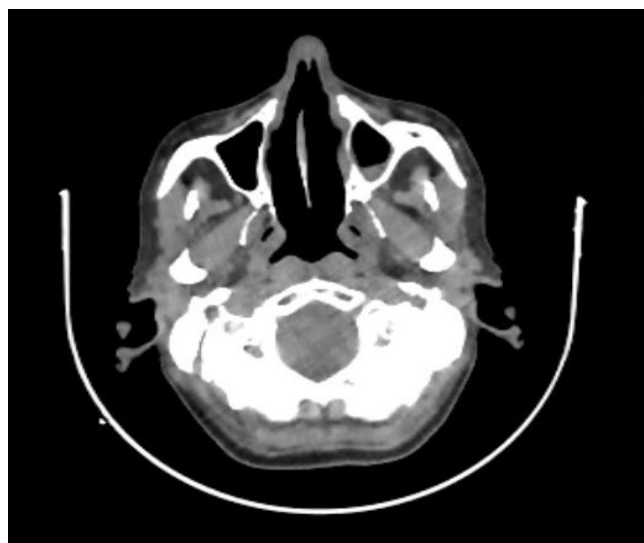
Cervical facia CT showing mucosal thickening in the left maxillary sinus with filling of the left ethmoidal cells, but without adjacent bone lysis
